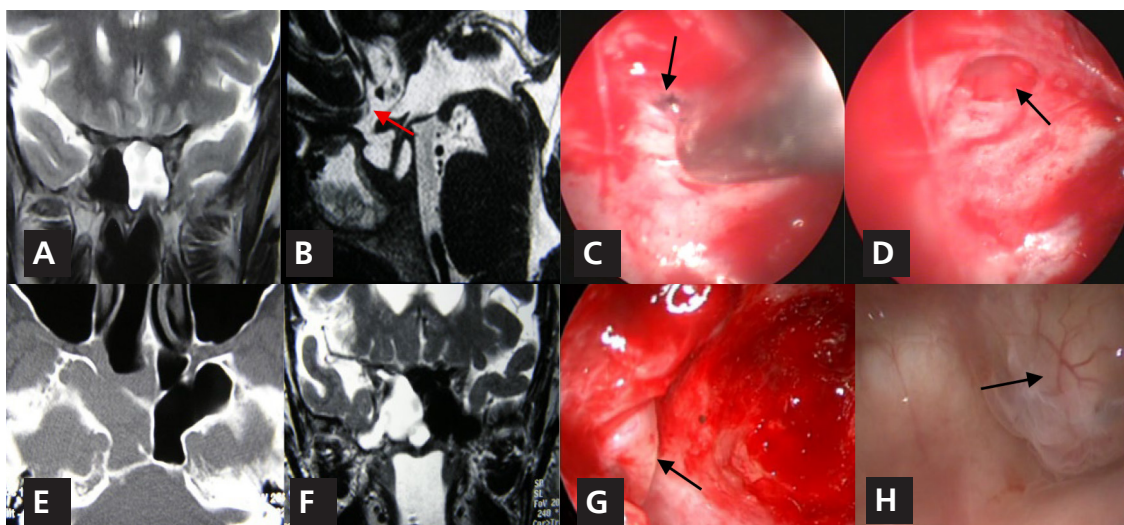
Meningoceles located at the sphenoid planum and sphenoid sinus with high-flow cerebrospinal fluid (CSF) leak. *Sphenoid planum meningocele.* (A) MRI showing accumulation of CSF in the left sphenoid sinus. (B) Sagittal MRI demonstrating CSF leakage with contrast through the defect in the sphenoid planum (arrow). (C) Endonasal endoscopic view after sphenoidotomy and bipolar reduction of the meningocele (arrow). (D) Osseous defect after resection of the surrounding mucosa (arrow). *Right lateral sphenoid sinus meningocele.* (E) CT scan showing laterally pneumatized and opacified right sphenoid sinus. (F) Occupation of the right sphenoid sinus by CSF. (G) Lateral sphenoid meningocele (arrow). (H) Sphenoid meningocele located on the left lateral wall of the sphenoid sinus (arrow).
